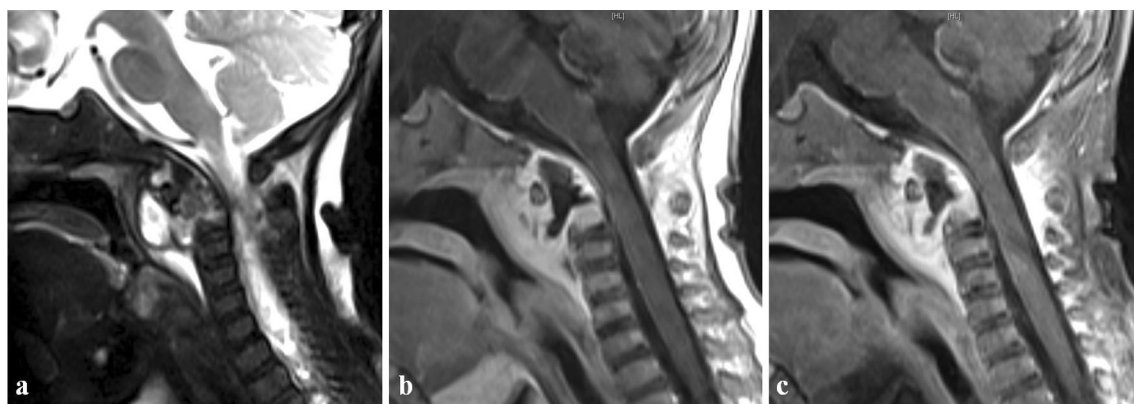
a The sagittal T2-weighted image consistent with large abscess in retropharyngeal space. b The sagittal T1-weighted image shows a large retropharyngeal abscess around the odontoid process
